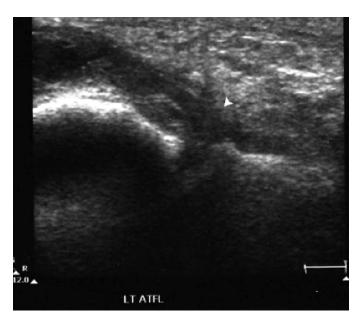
Diagnostic ultrasound of lateral aspect of left ankle. The arrowhead indicates the left ATFL is not intact.
